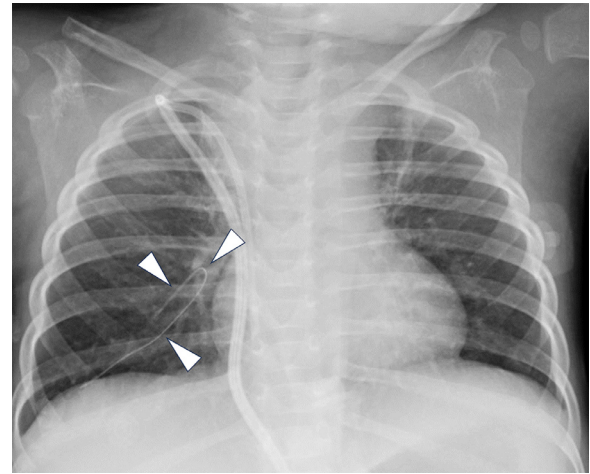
Chest radiography showing a folded linear foreign body in the right middle and lower lung areas (arrowheads).
